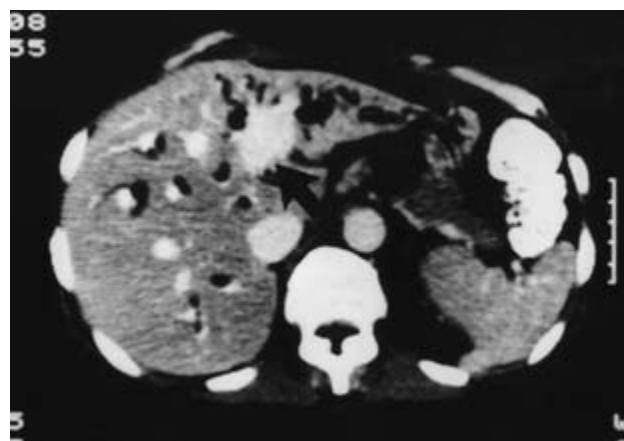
Caroli's disease. CT scan after intravenous contrast shows dilated intra-hepatic bile ducts with adjacent enhanced radicles of the portal vein.
